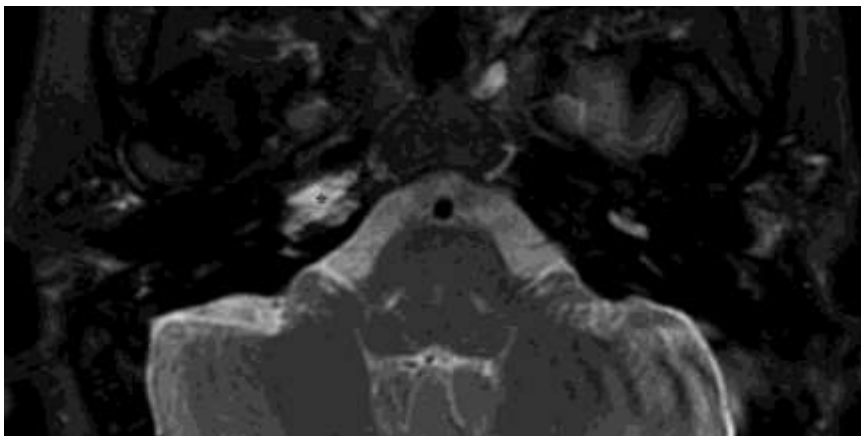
Petrous apicitis; axial T2-weighted turbo spin echo with fat saturation revealing an inhomogeneous fluid collection within the right petrous apex (asterisk).
